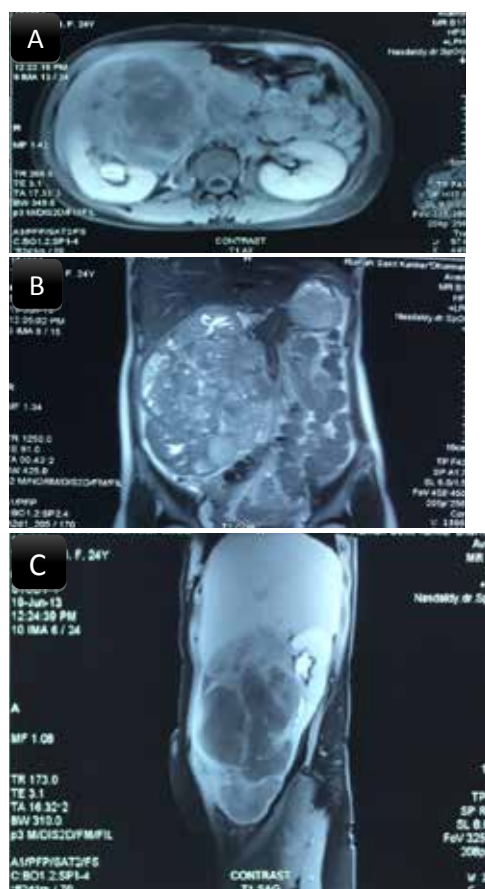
Pre-operative MRI, (A) T1-weighted + contrast axial view; (B) T2-weighted coronal view; (C) T1-weighted + contrast sagittal view.
